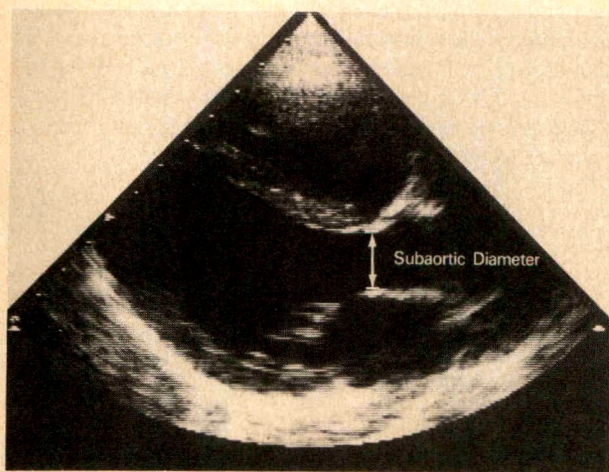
Parasternal long-axis cross-sectional echocardiographic image, showing measurement of the subaortic diameter.
